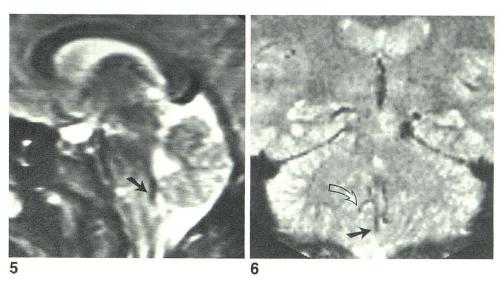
T2-weighted coronal image, SE 2500/80. Decreased intensity may represent CSF flow-void sign in foramen of Magendie (solid arrow) and right foramen of Luschka (open arrow) and/or branches of posterior inferior cerebellar artery.
